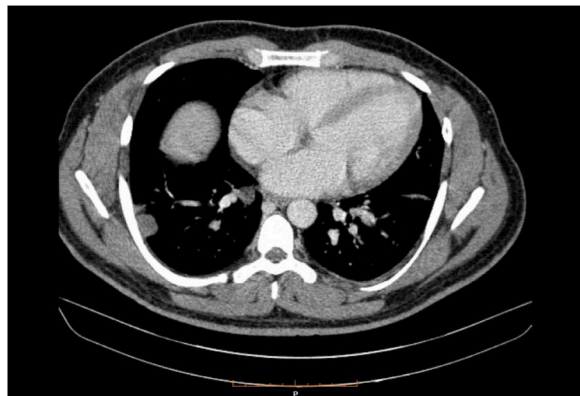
A Pulmonary Computed Tomography Angiography shows peripheral mass-like alveolar densities and bilateral pleural effusion.
